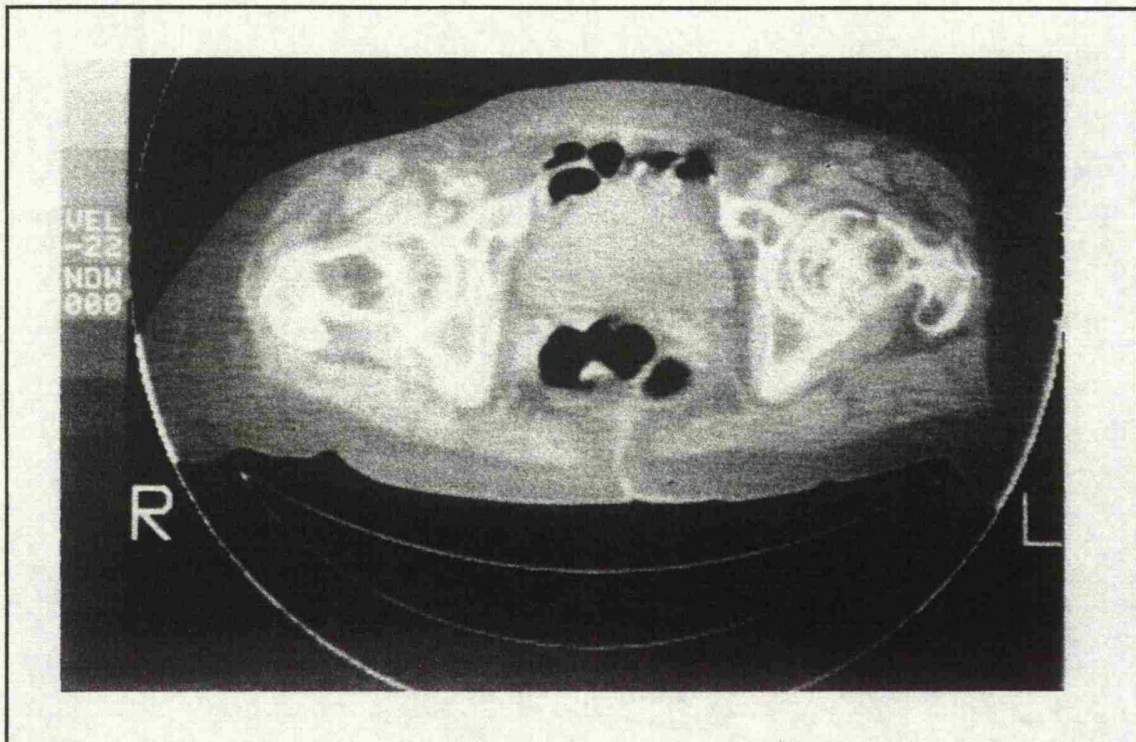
A CT scan showing a fracture which exhibits radiological features consistent with an old injury.
